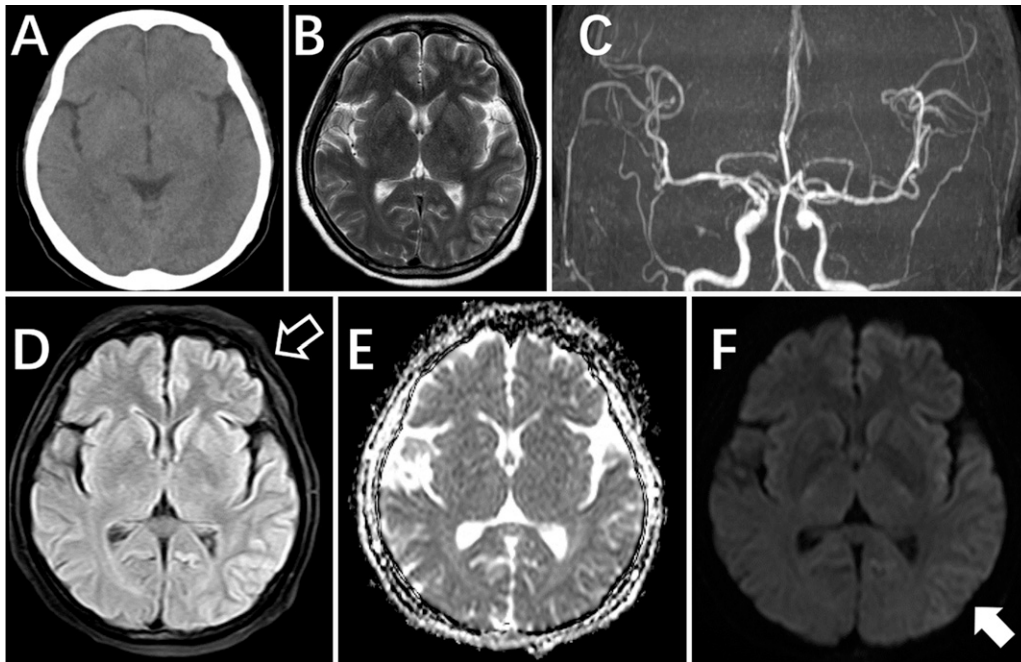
Head CT and head MRI findings after onset. A: CT revealed no obvious abnormality. B: No obvious abnormality was found on T2-weighted MRI. C: MRA was normal. D: FLAIR revealed a hyperintensity in the left cerebral hemisphere (*white hollow arrow*). E: ADC was normal. F: DWI revealed hyperintensities in the cortices of the left frontal, temporal, and insular lobes (*solid white arrow*).
